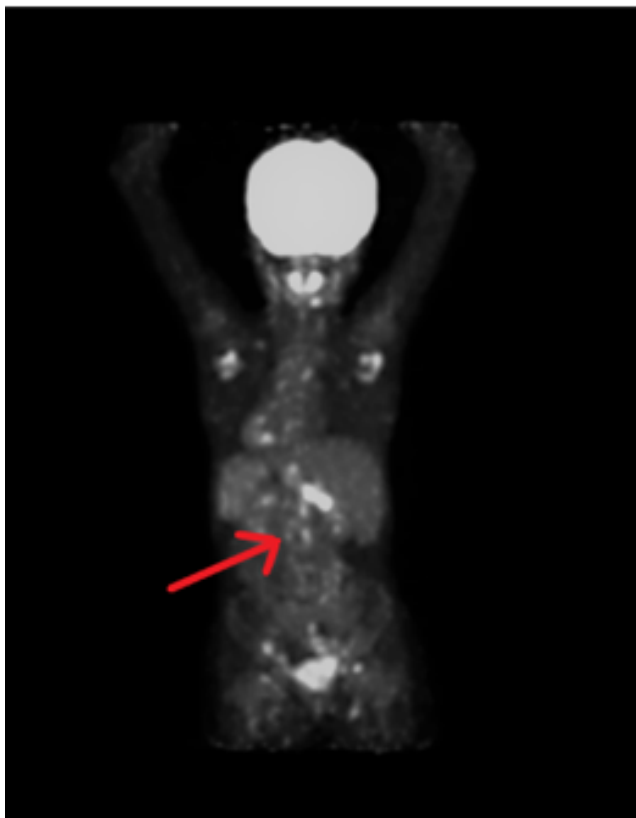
FDG-PET showing lack of uptake in greater vessels
